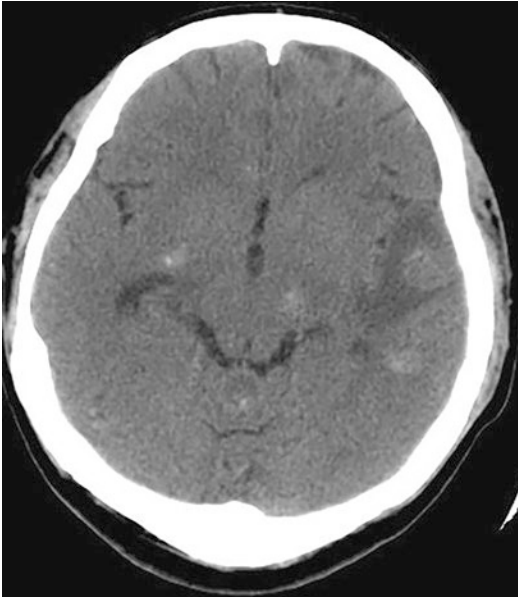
Axial non-contrast head CT demonstrates multiple parenchymal calcified lesions, some with mild surrounding edema characteristic of the nodular calcified stage of cysticercosis [9]. (Reprinted from Lungren et al. [9], with permission from SpringerNature)
